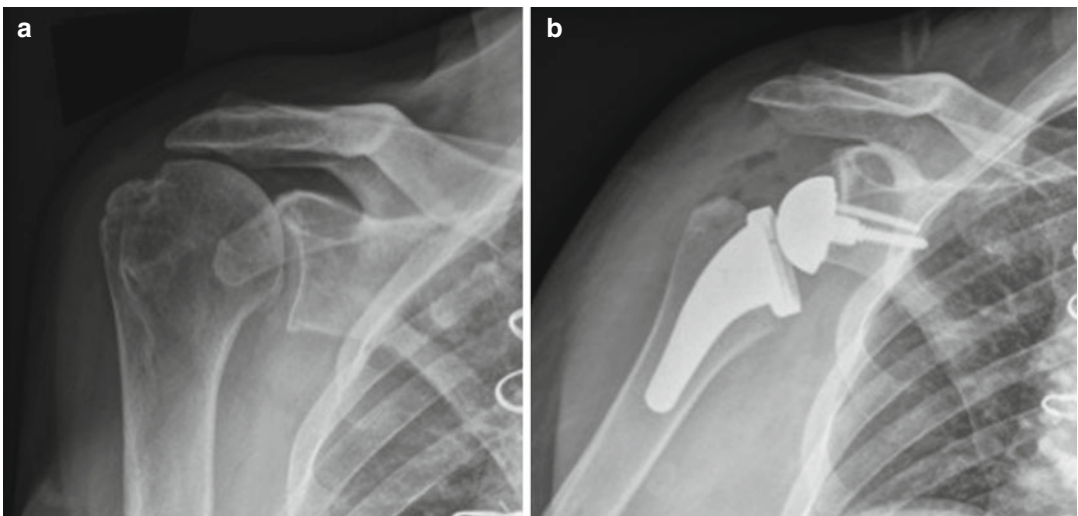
(a) Preoperative radiograph demonstrating Hamada grade 3 rotator cuff arthropathy and (b) postoperative radiograph after placement of a reverse total shoulder prosthesis
